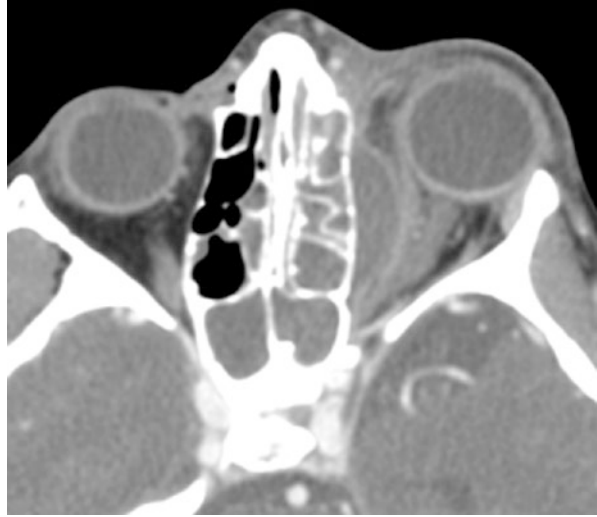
Axial CT scan demonstrating ethmoid sinusitis associated with a subperiosteal abscess of the left medial orbit. Despite the size of the abscess, these will often respond to medical therapy alone
